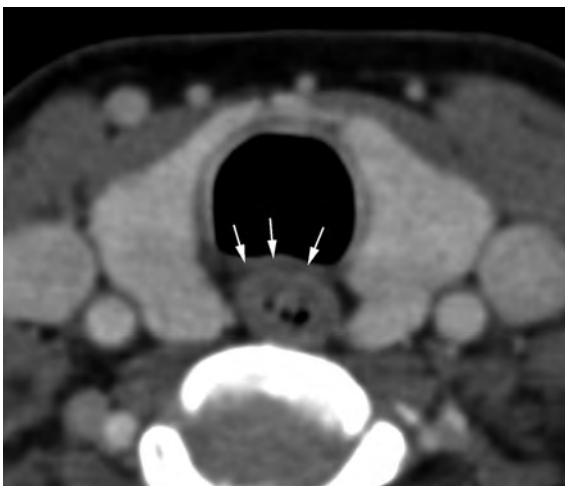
Axial contrast-enhanced CT image demonstrates the normal appearance of the common wall of the trachea and esophagus with a thin layer of fat (arrows) visualized between the trachea anteriorly and the esophagus posteriorly
